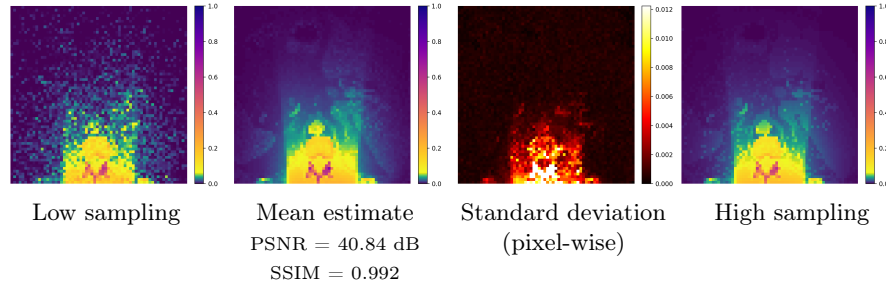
Sampling-based reconstruction variability with the conditional DDPM. For fixed LS and CT inputs, the model is sampled $K = 5$ times from independent Gaussian noise realizations. The mean and pixel-wise standard deviation are shown with the HS MC reference.
